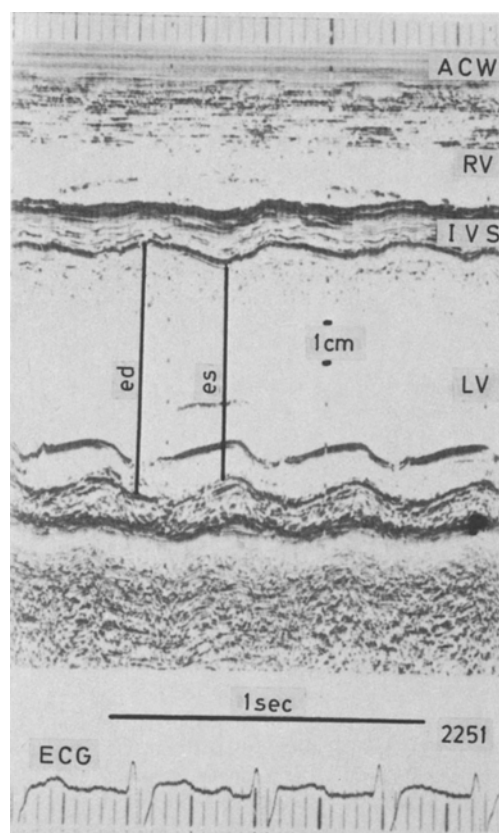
Echocardiogram obtained in a patient with doxorubicin cardiotoxicity. The LV end-diastolic (ed) dimension is increased to 6 cm (normal value in adults is 3.0–5.3 cm). The % FS of the left ventricle (normal 25%) is reduced to 15%. There is a symmetric reduction of the contraction of the interventricular septum (IVS) and of the posterior wall indicating diffuse myocardial disease. ACW, anterior chest wall; RV, right ventricle; LV, left ventricle; ed, end-diastole; es, end-systole; P, pericardium
